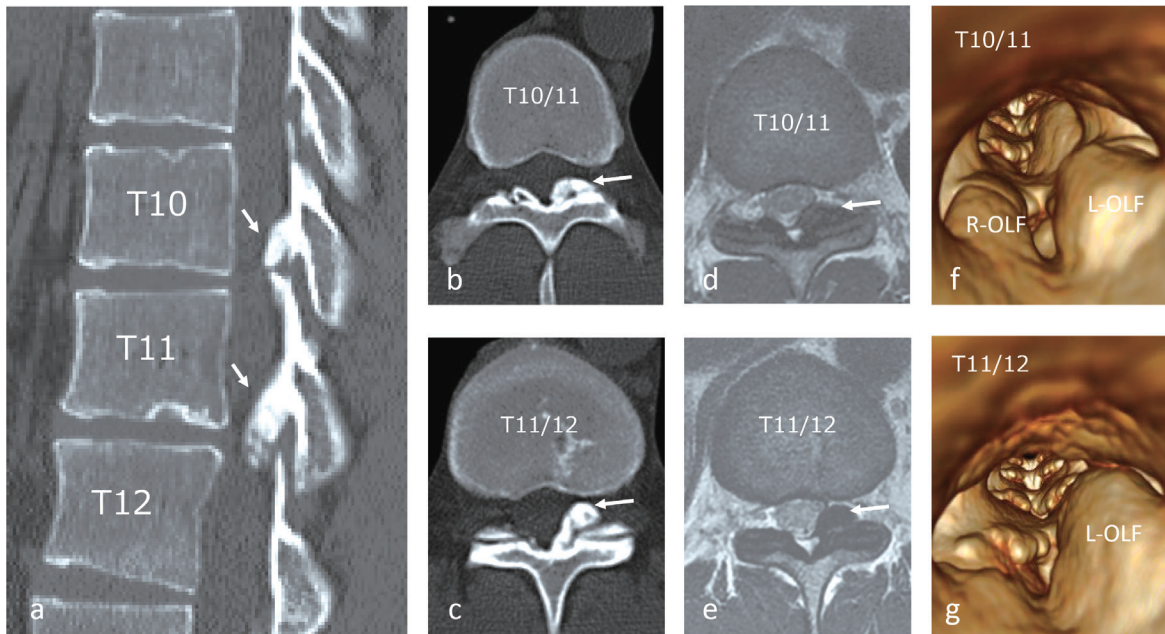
Sagittal (a), axial at T10/11 (b), and T11/12 (c) computed tomography (CT) scan revealing the presence of OLF (arrows). Axial T2-weighted magnetic resonance imaging (MRI) demonstrated dural tube compression by OLF situated postero-laterally at T10/11 (d) and T11/12 (e) levels. 3D-CT (spinal canal view at T10/11(f) and T11/12(g)) of the thoracic spine showing the stenosis of the spinal canal.
